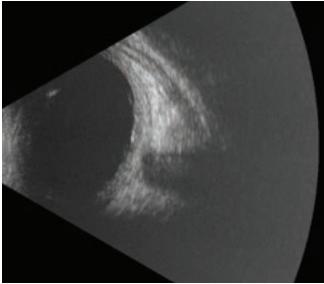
B-scan ultrasonography showed choroidal thickening in the right eye.
